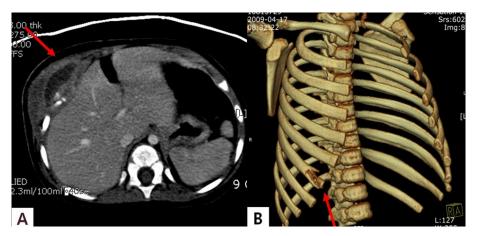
CT scan of the chest showed empyema necessitatis at the right lower chest and upper abdominal walls with osteomyelitis of the right 7th rib. (A) Axial scan of the chest and upper abdomen, (B) 3D- reconstruction of the bony chest wall.
